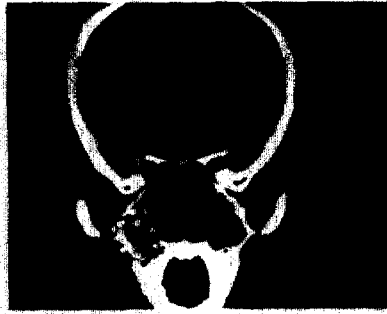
Computed tomography on the lesion. The relatively well marginated soft tissue mass with multiple calcifications and destruction of the posterolateral wall of the right maxillary sinus and alveolar process of the maxilla were noticed.
